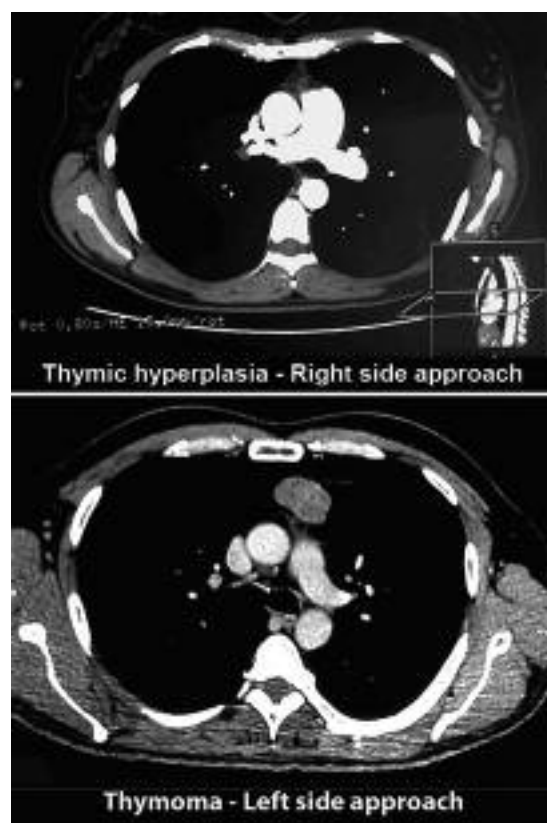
Chest CT scans – Radiographic manifestations of thymic pathology in MG*
